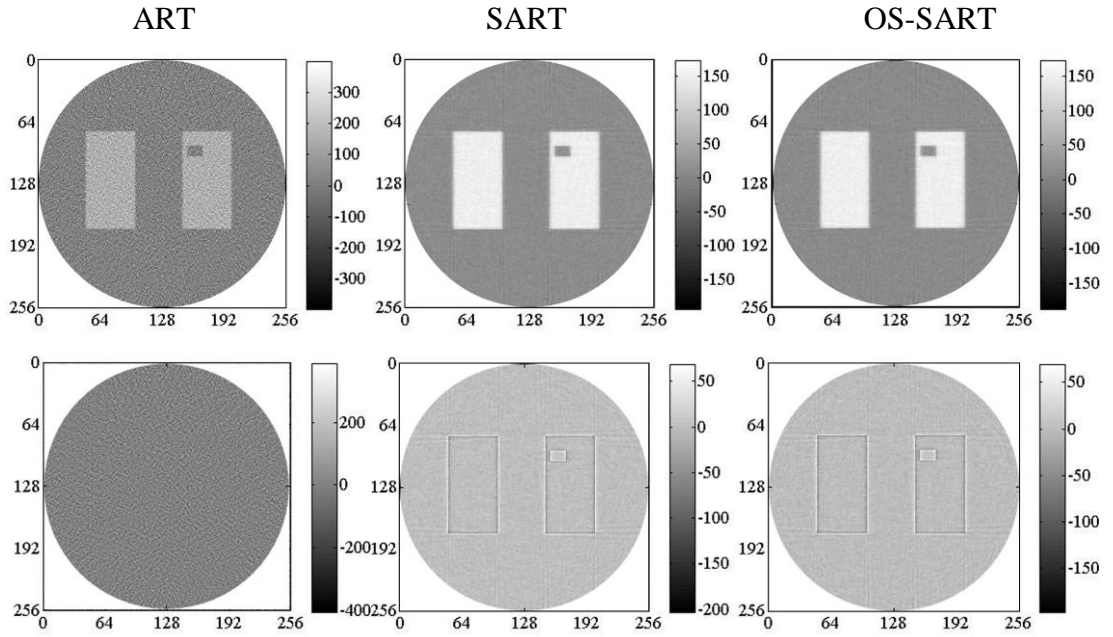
CBCT reconstruction after the 100th cycle for inconsistent case using ART, SART, and OS-SART ($\alpha = 0.01$): top row is reconstructed images, bottom row is error images.
